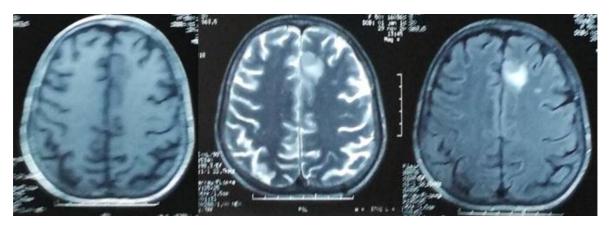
MRI sequences showing the left frontal lesion
